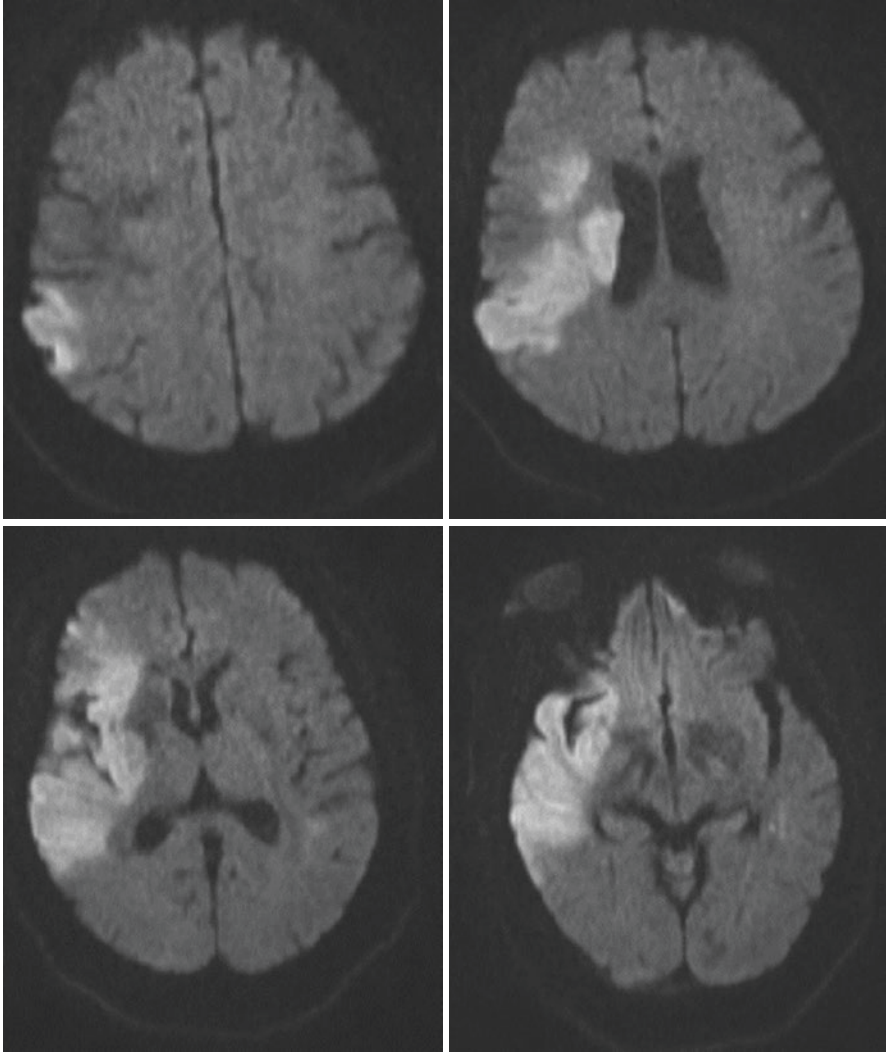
MRI brain diffusion weighted sequence (DWI) of the patient prior to mechanical thrombectomy. Depicted in the picture below are axial cut sections from a DWI sequence of MRI Brain of the patient with right middle cerebral artery infarct. This imaging was performed as a part of evaluation for mechanical thrombectomy since her last known normal was unknown and she was post operative day 1 post surgery. The imaging shows sparing of some of the deeper structures and posterior temporal lobe supplied by the middle cerebral artery
